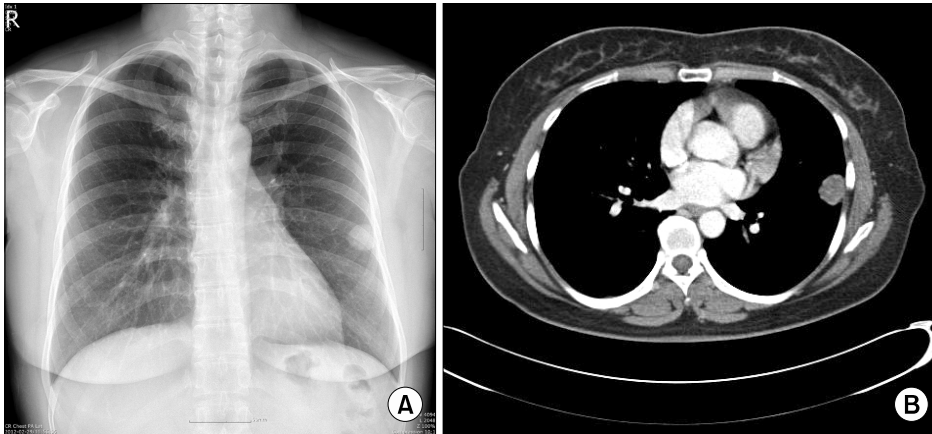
(A) Preoperative chest radiography and (B) computed tomography reveal a well-defined mass of 3×2.9 cm that borders the visceral pleura at the left upper lobe lingular segment.
